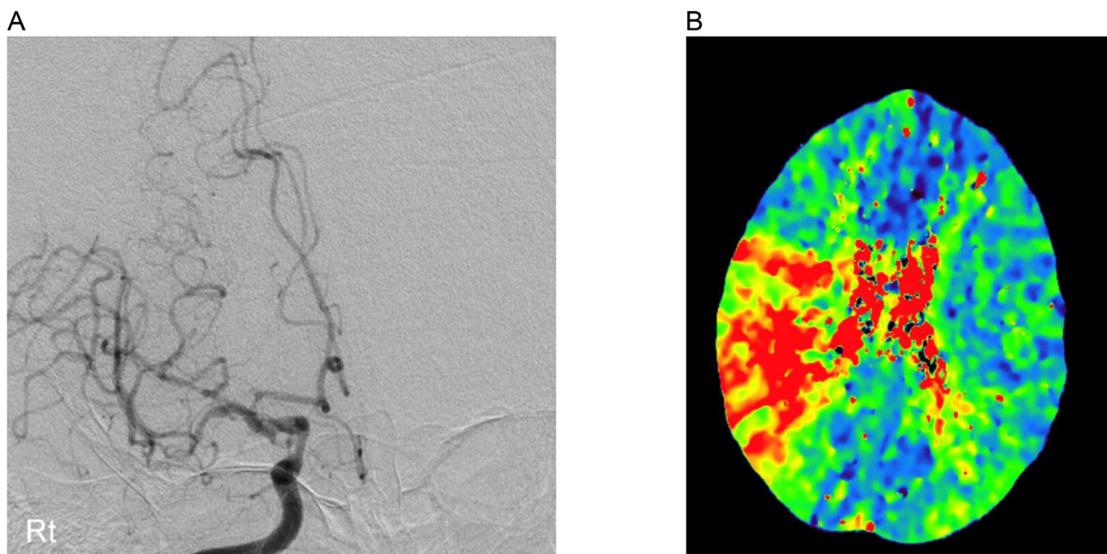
(A) Right ICA angiogram, case #1: moderate stenoses of supraclinoid right ICA, MCA and ACA. (B) TTP CT perfusion image, case #1: marked delay in right MCA territory.
